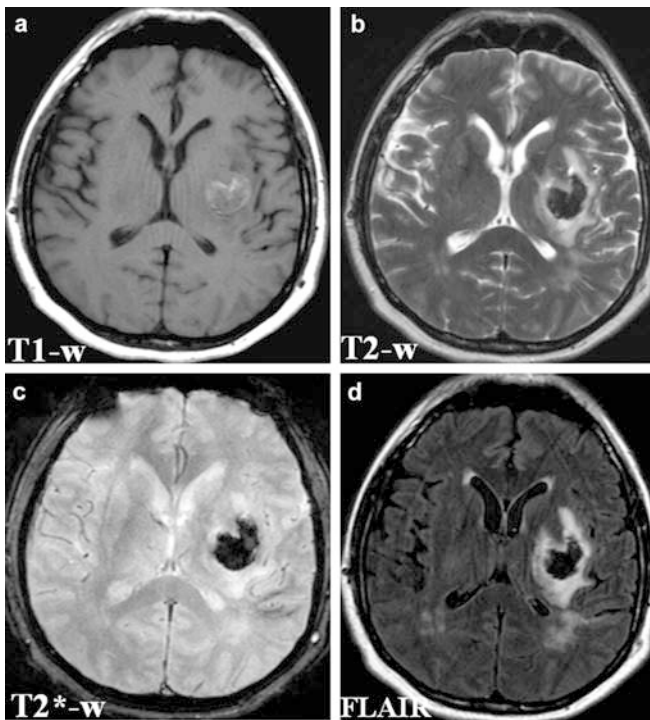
A 17-h-old haematoma with T1- (a) and T2-weighted (b) SE sequences, T2*-weighted GE (c) and fluid-attenuated inversion recovery (FLAIR) (d). This lesion showed early hyperintense signal intensities on T1-weighted SE (a)
